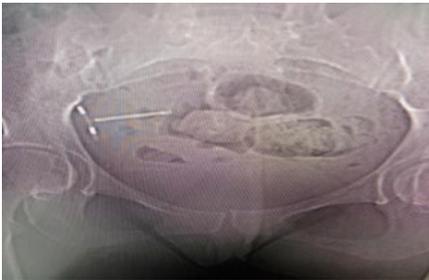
Coronal Reformatted CT
